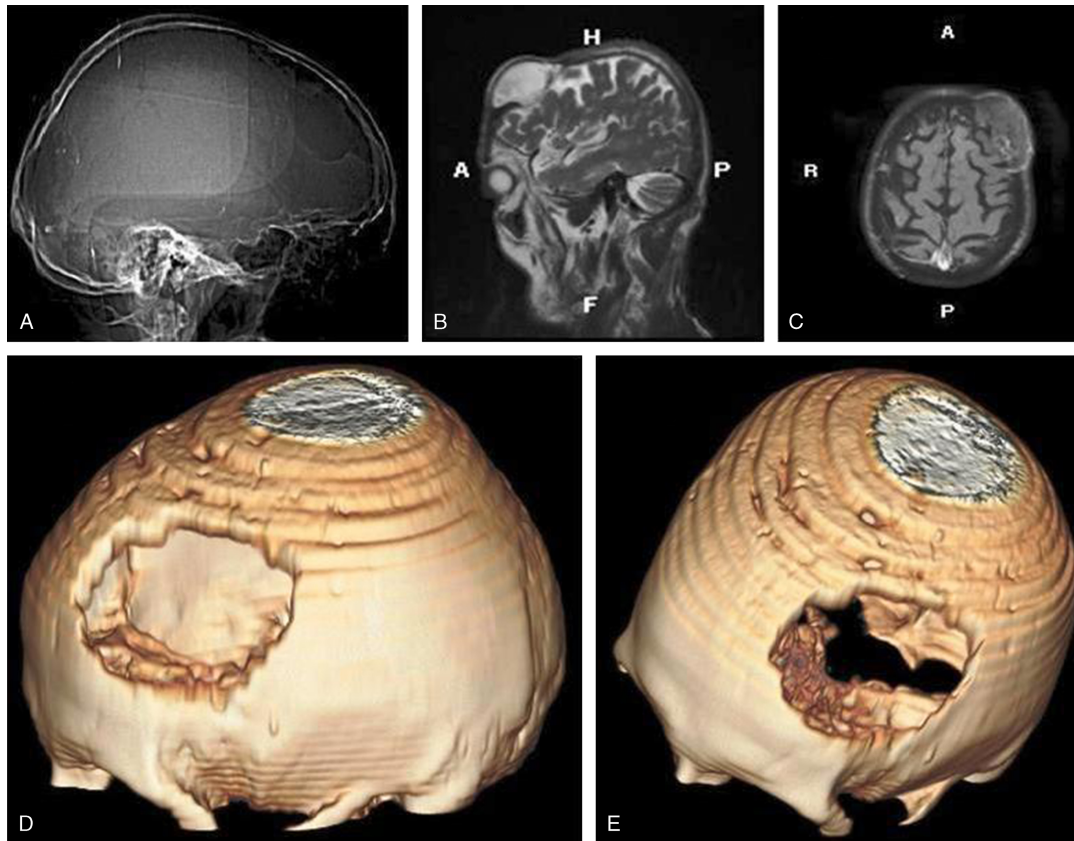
A, The expansile, regular lesion located in the left frontal region, eroding the inner and outer tabulae, is seen on the skull x-ray film. B, The lesion is seen to have a hyperintense-signal characteristic on T2-weighted sagittal MRI. C, The lesion is seen to have mixed-intense signal characteristic on T1-weighted axial MRI. D and E, The mass lesion is seen to completely erode the bone inward and outward on three-dimensional tomographs.
